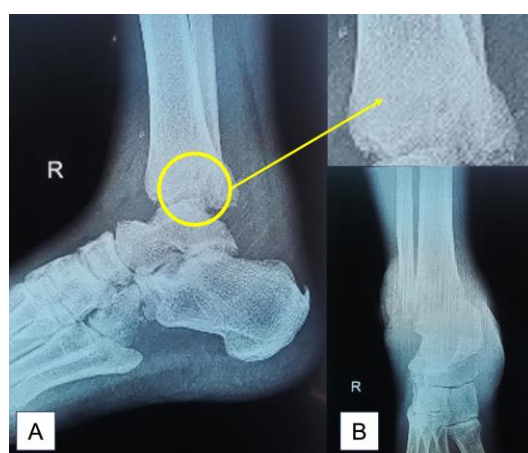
(a) AP/LAT radiograph of ankle joint osteomyelitis with epimetaphyseal fracture of the distal 1/3 of the right fibula with (b) soft tissue swelling.
